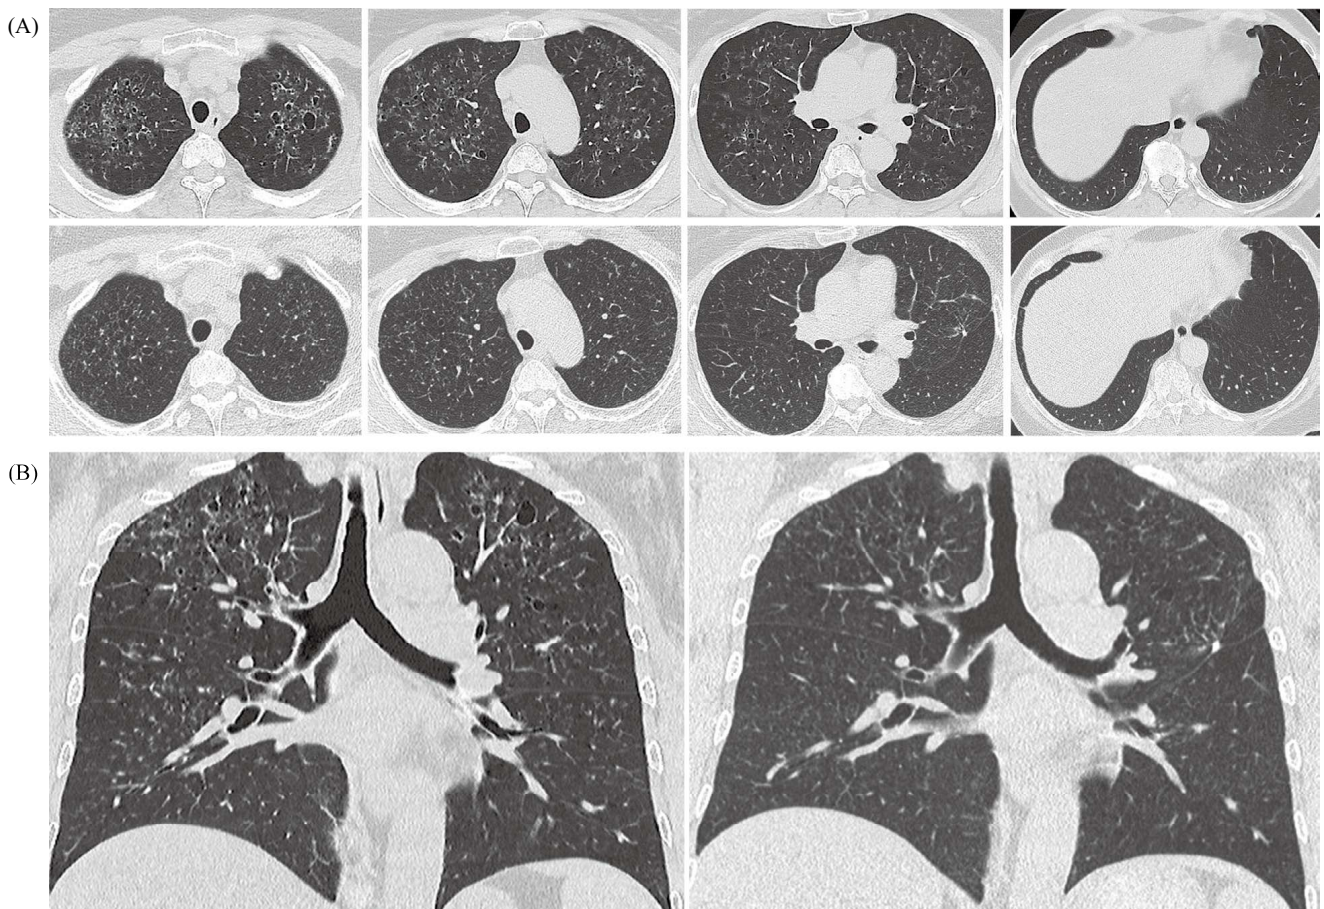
(A) Transverse-view computed tomography (CT) images at initial presentation (upper panels; 2-mm slice) and 12 months later (lower panels; 1-mm slice). The scar from the wedge biopsy is visible in the left lung field. (B) Coronal-reconstruction CT images at initial presentation (left panel; 2-mm slice) and 12 months later (right panel; 1-mm slice).
